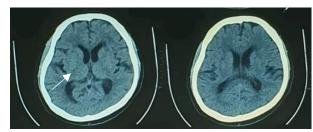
Head CT scan showed acute cerebral infarct at the right basal ganglia (white arrow).
